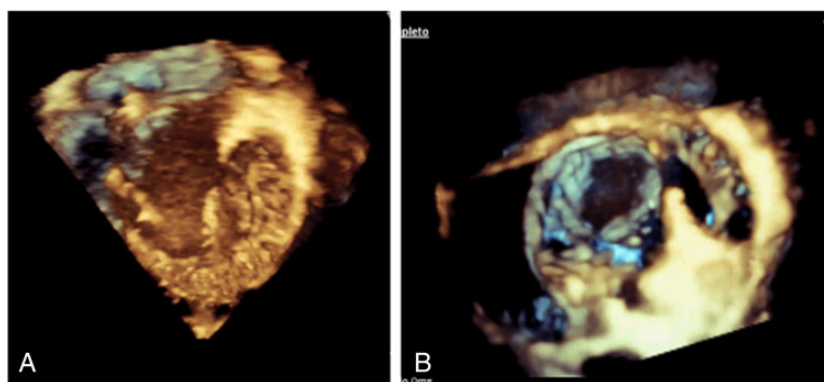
3D echocardiography of the RV. (A) Long axis 3D reconstruction of the RV. (B) Tricuspid valve seen from above (atrial prospective).
